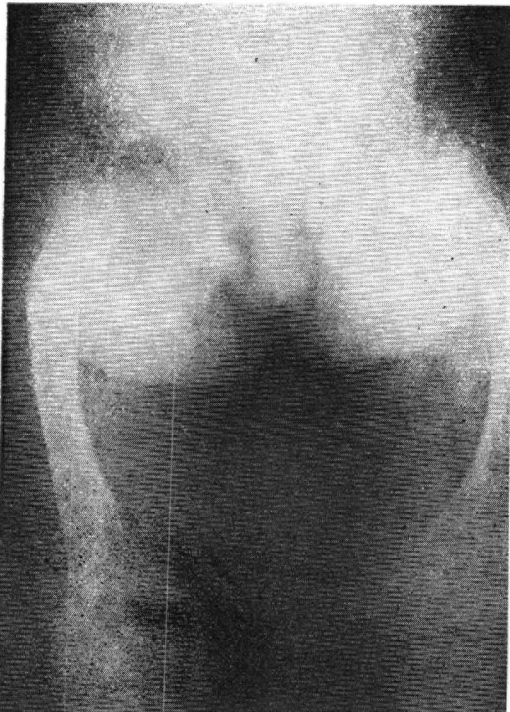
X-ray of pelvis and femora. Showing marked osteoporosis.
